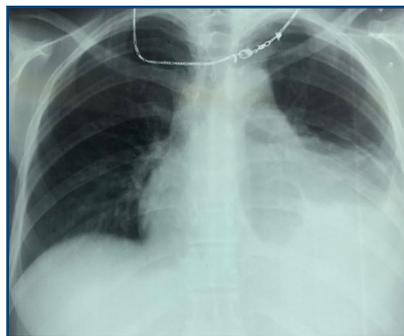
AP chest x-ray: Left pleural effusion
